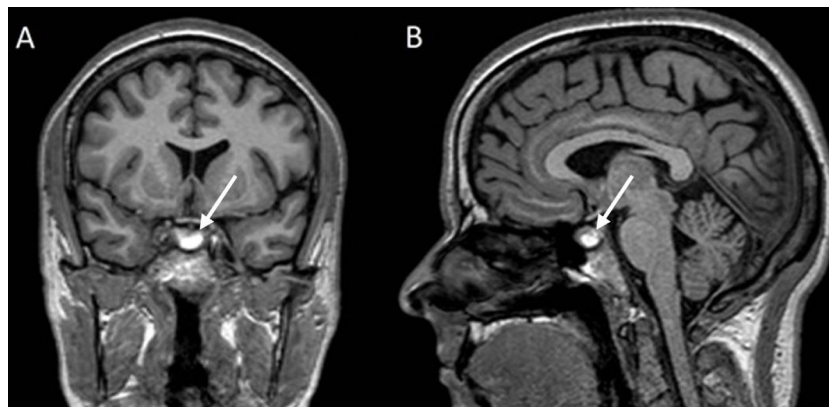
Coronal (A) and sagittal (B) slices of the skull MRI. Adenohypophysis hemorrhagic bleeding in association with a possible 10 mm intraglandular adenoma without chiasmatic involvement.
